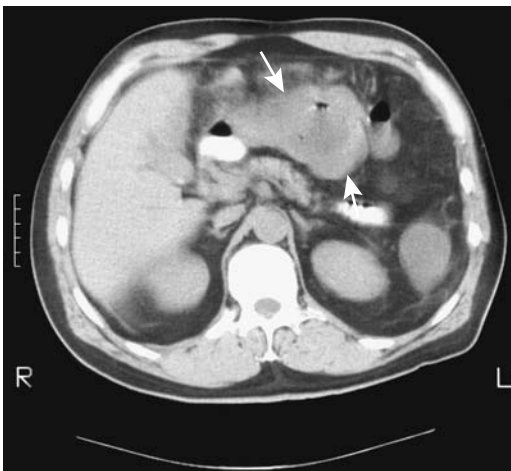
Leiomyoblastoma. CT identifies a soft-tissue density tumor (arrows) containing a lucent center and focal gas. It was believed initially to represent an abscess.
